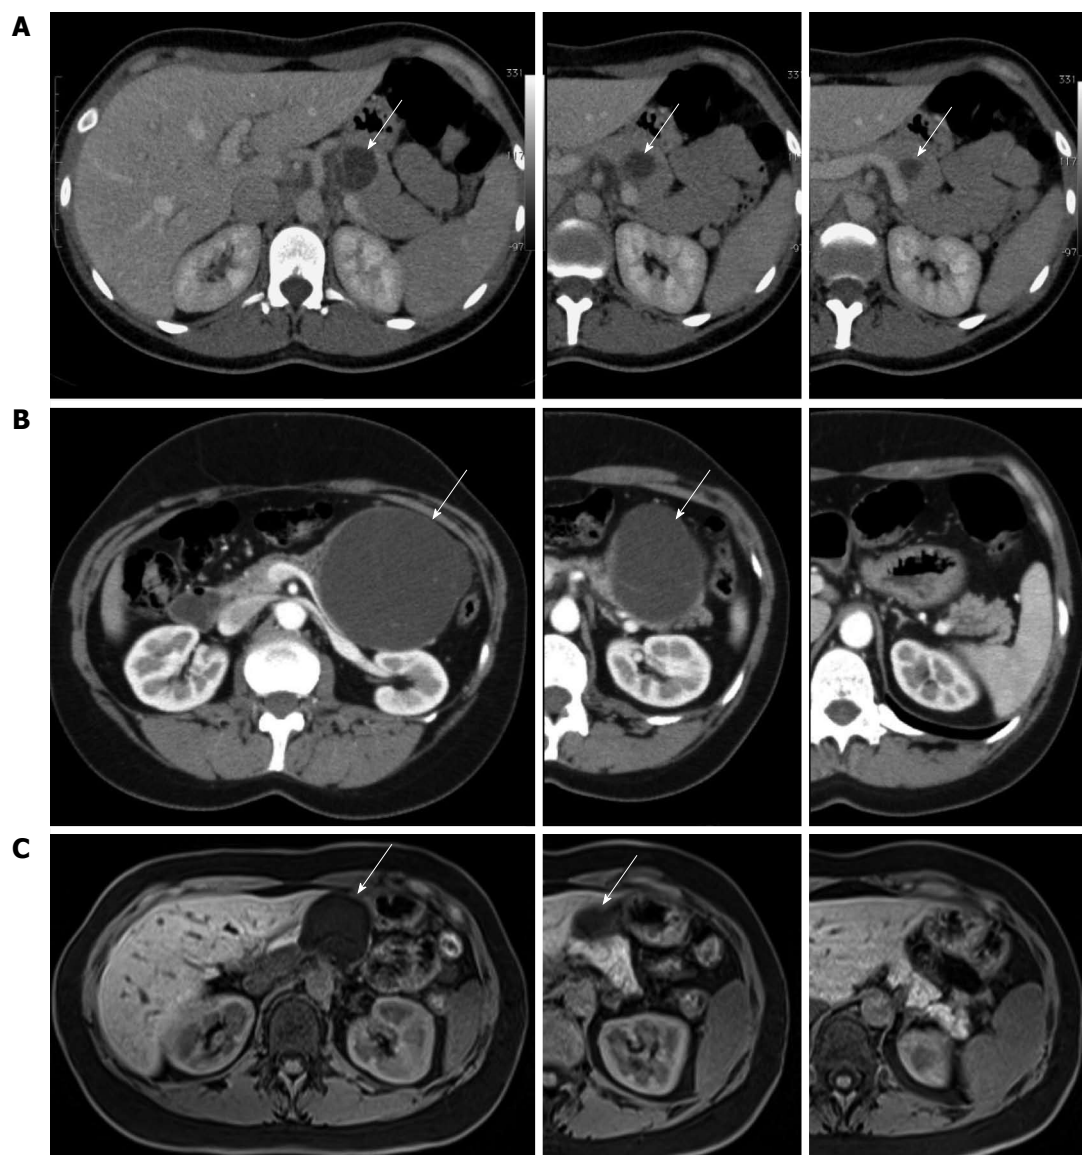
Abdominal computed tomography scan. A: Abdominal computed tomography (CT) scan showing a 4 cm pancreatic cystic lesion of the neck in patient 1; B: Abdominal CT scan showing a 10 cm pancreatic cystic lesion of the body in patient 2; C: Abdominal magnetic resonance imaging showing a 4.6 cm cystic lesion of the neck in patient 3. Arrows mark the cystic lesion (A-C).
